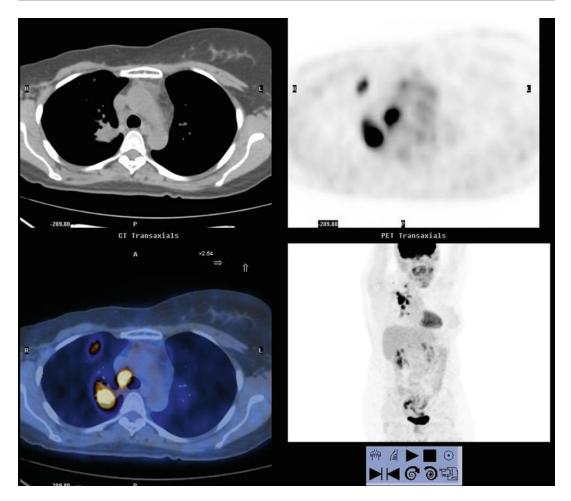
This is a patient with a right upper lobe lung cancer with FDG avid mediastinal nodes (*lower right*). The PET/ CT image (*lower right*) shows the FDG uptake in the primary and right paratracheal nodes
